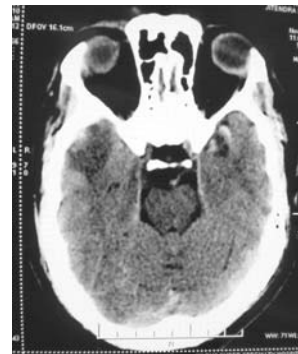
CT SCAN BRAIN; Showing bilateral temporal lobe contusions with surrounding oedema
